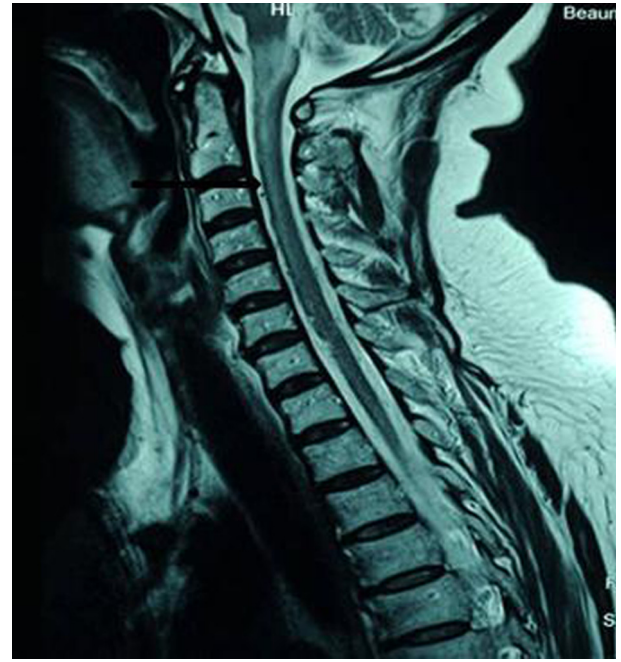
MRI cervical spine showing cord swelling with vascular flow voids.
